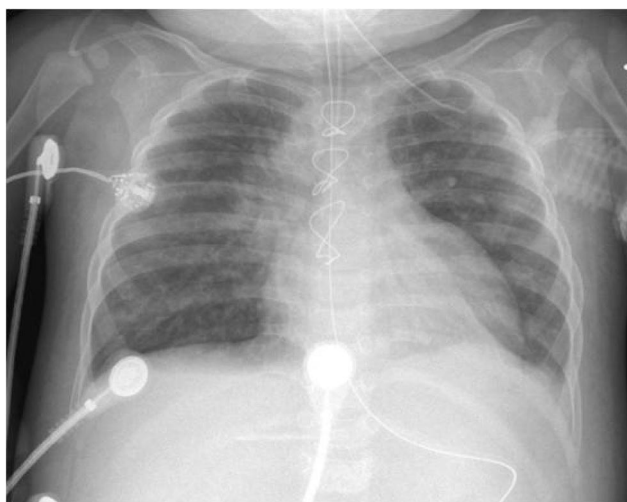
Chest radiograph on pediatric intensive care unit day 7, prior to cannulation for venovenous extracorporeal membrane oxygenation, shows stable lower-lobe and perihilar atelectasis, but no other important changes.
